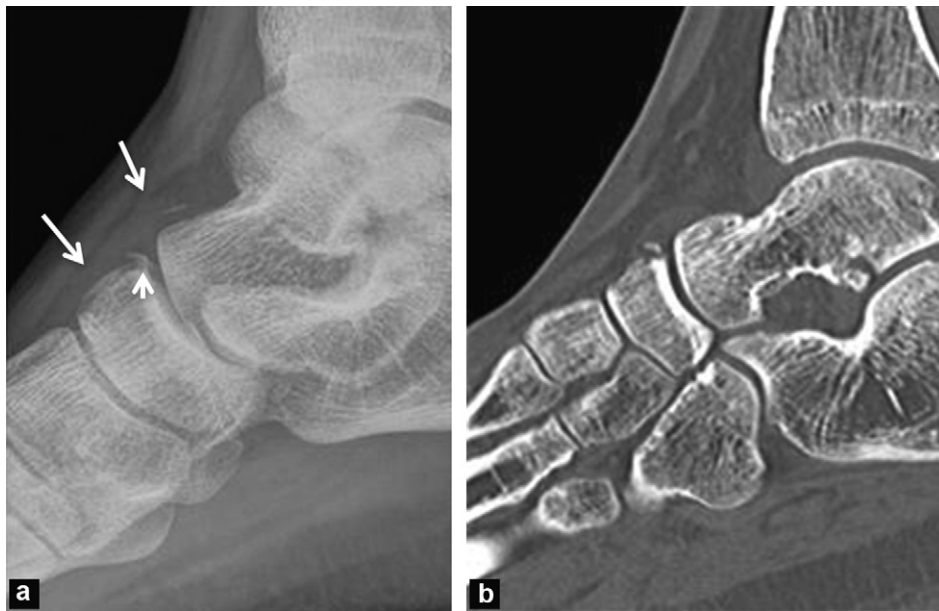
Chopart sprain. Thickening of the soft tissue (long arrows) and avulsion of the navicular insertion of the dorsal talonavicular ligament (short arrow). a: X-ray; b: CT (sagittal reformat).
